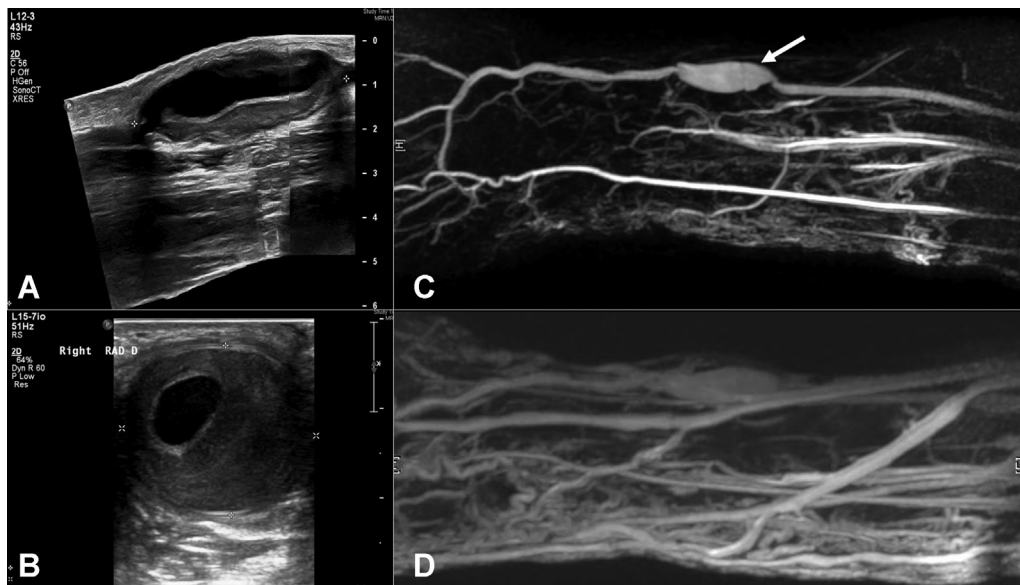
A, Duplex ultrasound scan showing longitudinal view of the right radial artery aneurysm. B, Duplex ultrasound scan showing the cross-sectional view of the right radial artery aneurysm (RRA), mural thrombus, and flow channel. C, Magnetic resonance angiogram showing the RRA flow channel (arrow) and the ulnar artery. D, Magnetic resonance venous phase showing the arteriovenous malformation (AVM), which consisted of numerous corkscrew-like, enlarged, rapidly filling veins, with some cystic areas likely representing lymphatic structures within the subcutaneous tissues along the dorsal and ulnar aspect of the hand, wrist, and forearm.
